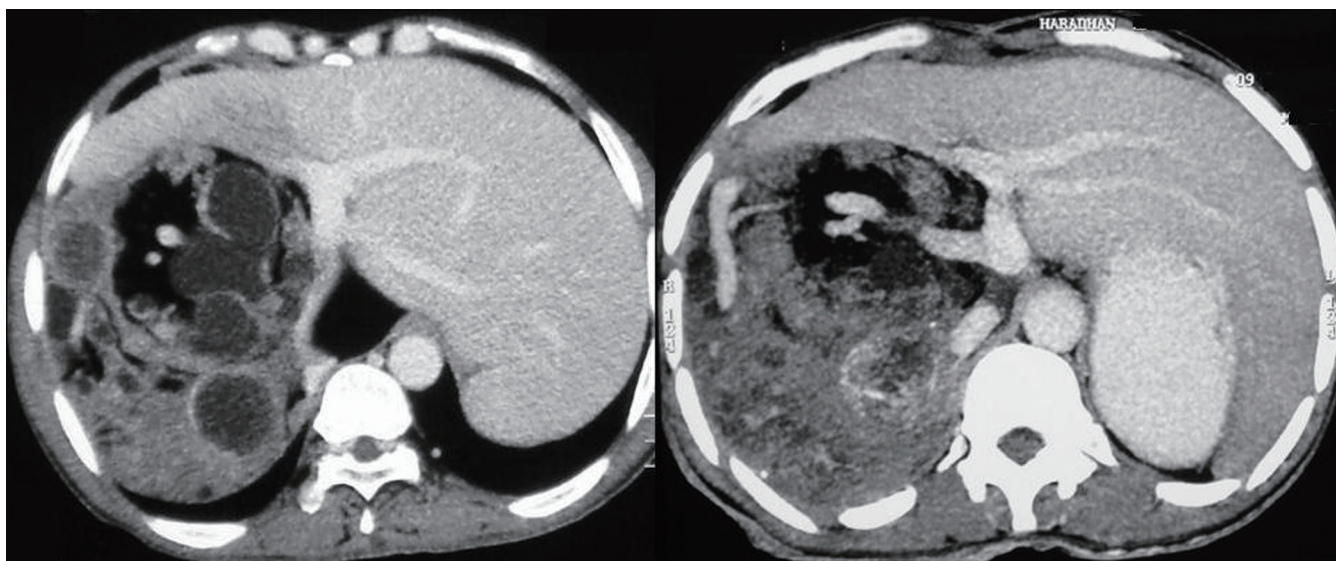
Contrast enhanced CT scan demonstrates a large, well-defined, heterogeneously hypodense lesion in the right lobe of liver comprising of multiloculated cysts with fine calcifications in the wall, mildly enhancing soft tissue component and small amount of fat. Encasement of the right hepatic vein, right branch of portal vein and hepatic artery is noted predominantly by the fatty component of the lesion
